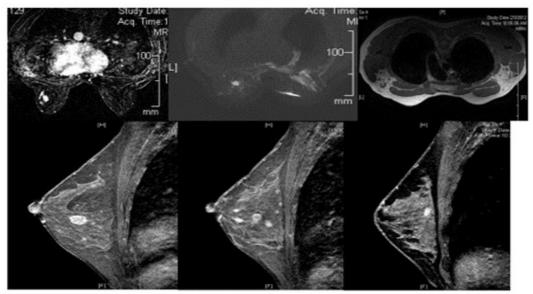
Rounded lesion of altered signal intensity seen in the left breast (a), showing restricted Diffusion on DWI (b). Left axillary node is enlarged with cortical thickening (c).
